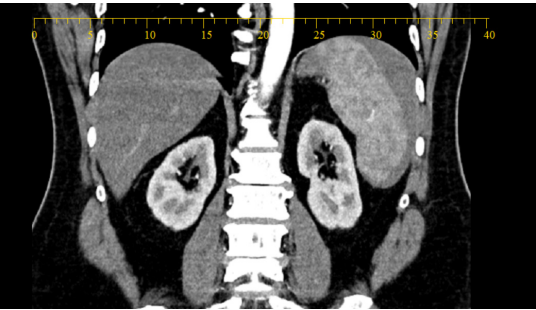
Contrast-enhanced CT of the abdomen and pelvis demonstrating moderate hemoperitoneum surrounding the spleen, without evidence of active contrast extravasation.
